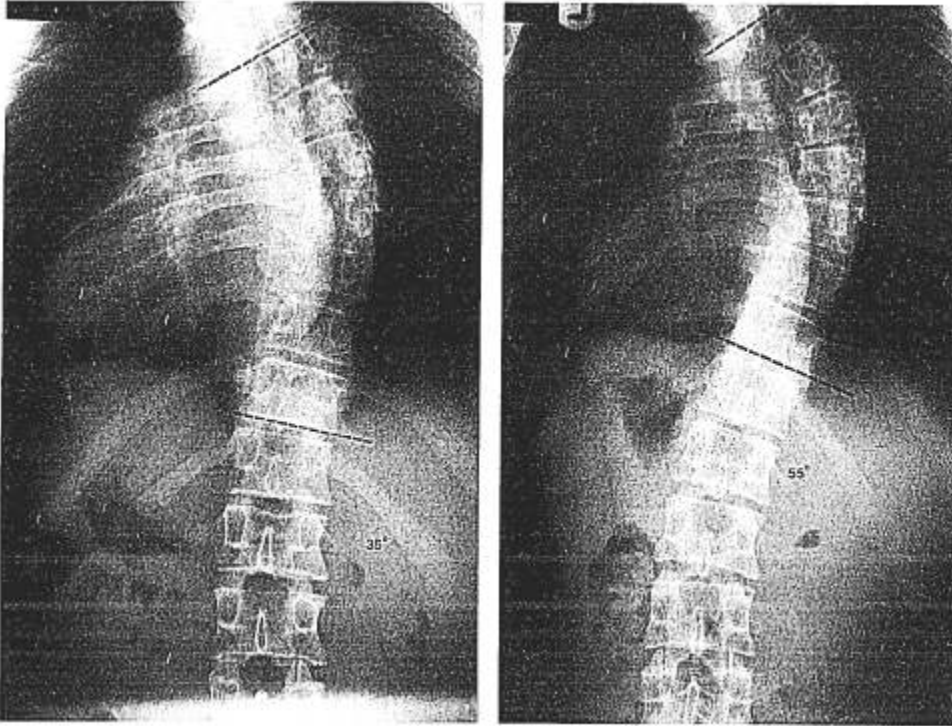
Preoperative anteroposterior and lateral radiographic films, demonstrating the deformity before and after horizontal traction.
